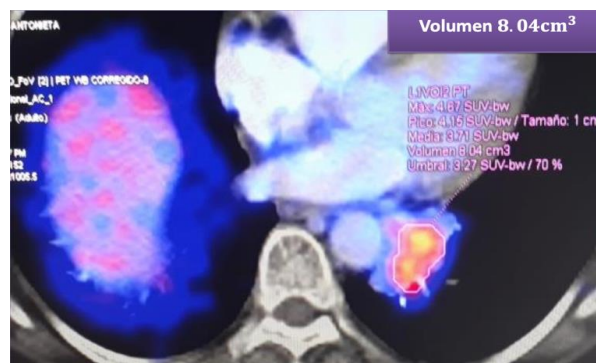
PET/CT Gallium 68 DOTA TOC 2016 tumor presented a volume of 8.04 cm³ corresponding to a reduction in size of 28%
